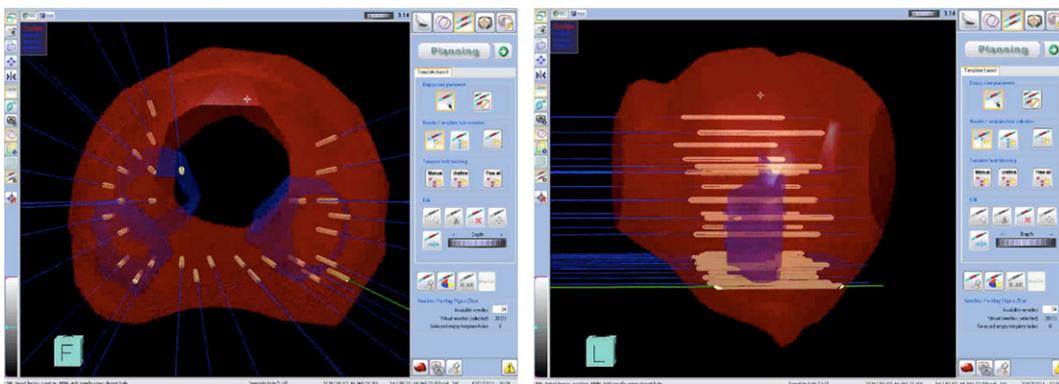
Biopsy cores were planned virtually in 3D data set using MRI and TRUS data. Biopsies were taken from suspicious lesions
